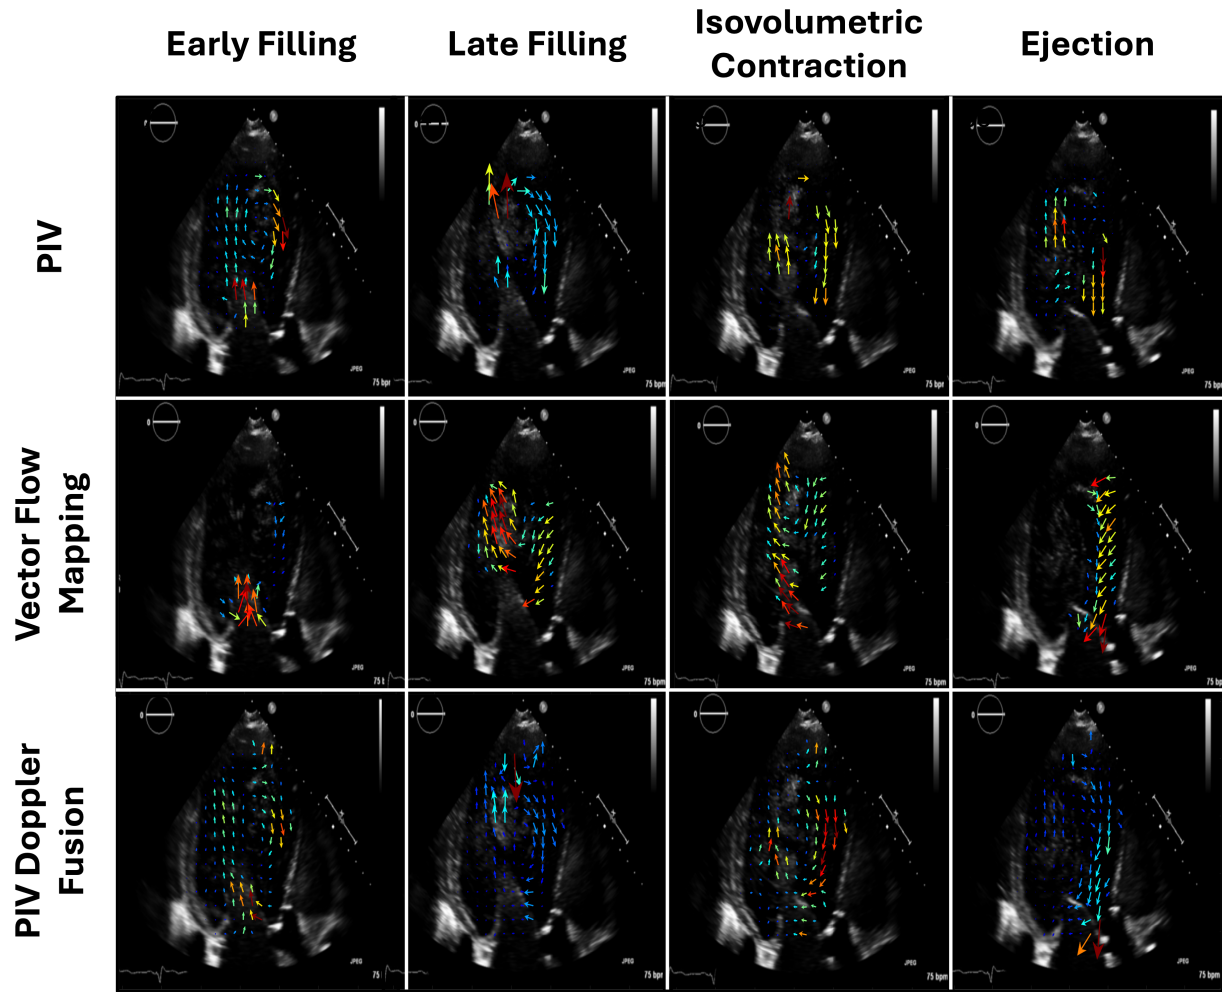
Comparison of PIV, Vector Flow Mapping, and Echo-PIV Color-Doppler Fusion: Three left ventricular (LV) flow quantification methods were applied to patient data at four key points in the cardiac cycle: early LV filling, late LV filling, isovolumetric contraction, and ejection. Row 1 shows the PIV velocity fields derived from ultrasound contrast images. Row 2 presents the vector fields obtained using classic Vector Flow Mapping. Row 3 displays velocity fields from the echo-PIV color-Doppler fusion method. Qualitatively, the fused data set combines the comprehensive spatial coverage of PIV with the high-velocity detail captured by color-Doppler, resulting in a richer and more informative flow field.
